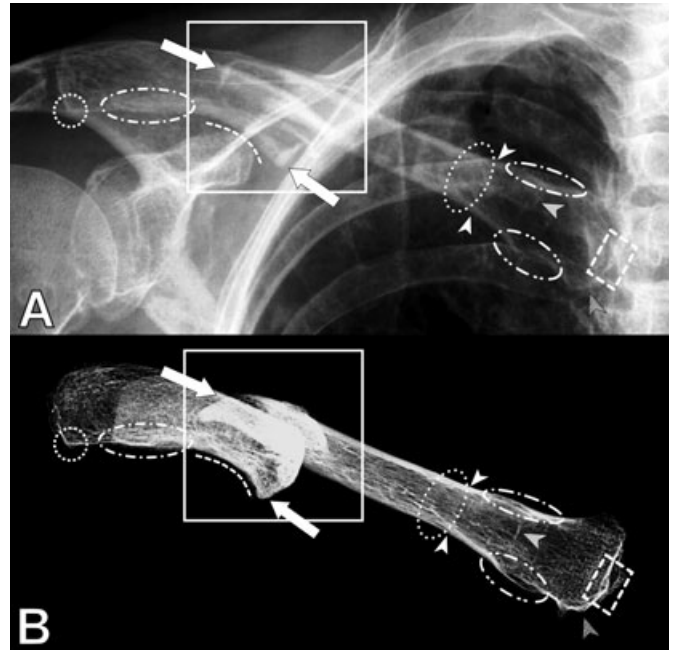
Right clavicle antemortem radiograph (A) and postmortem radiograph (B). Large white box shows alignment at fracture location, large white arrows identify change in bone shape at fracture margins. Highlighted points of concordance are presented in Table 1.
